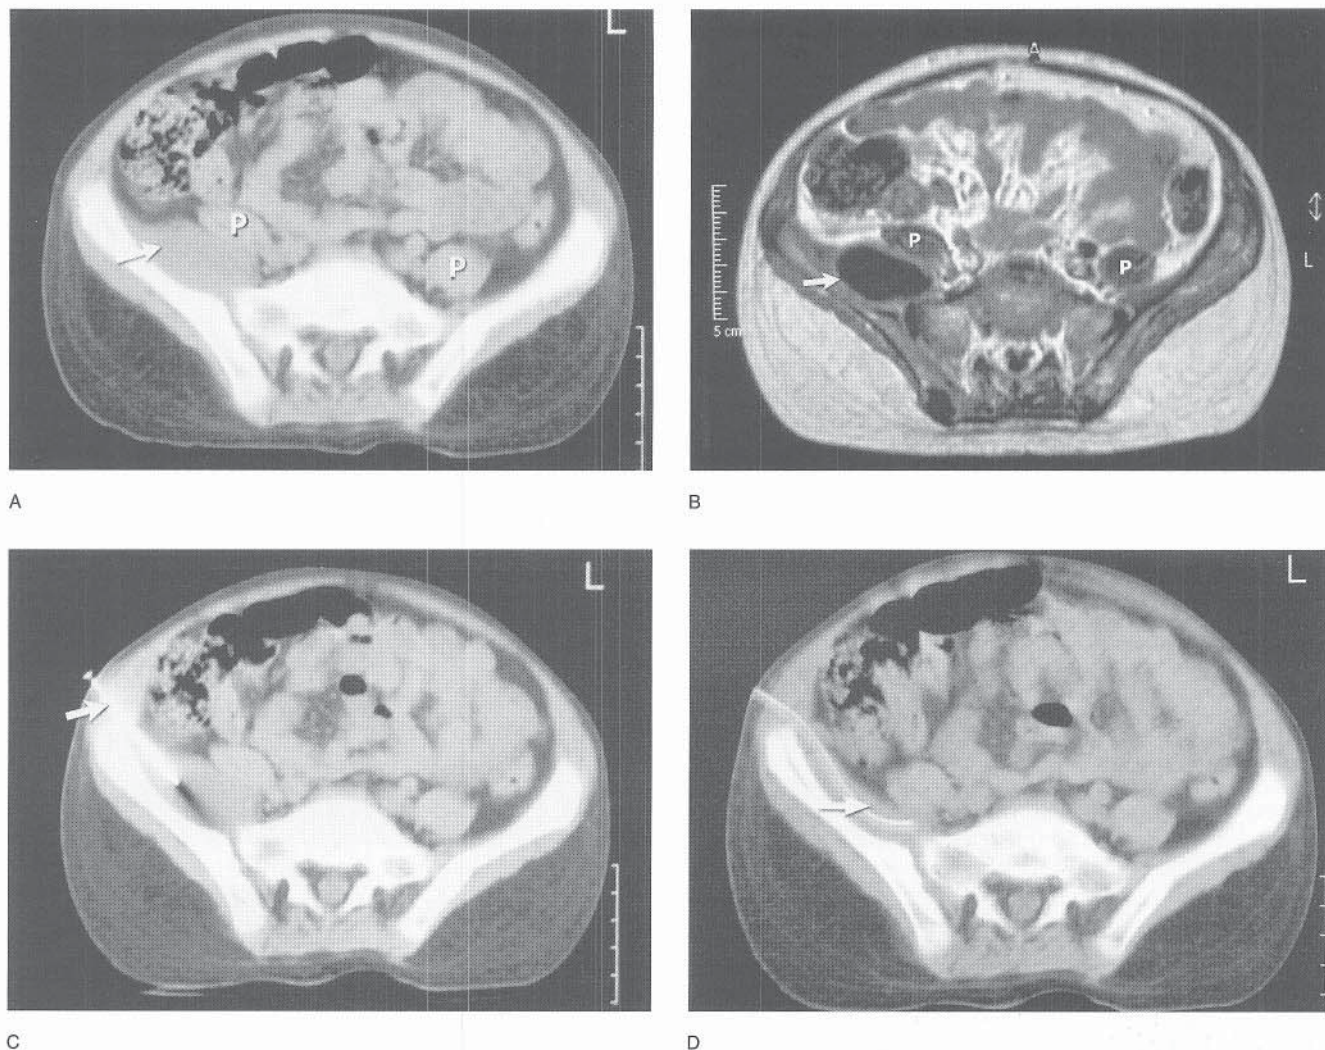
CT scan (A) and MR image (B) demonstrating a psoas abscess (arrow) displacing the right psoas muscle (P). CT-guided percutaneous drainage (C) with placement of a drainage tube (D).
